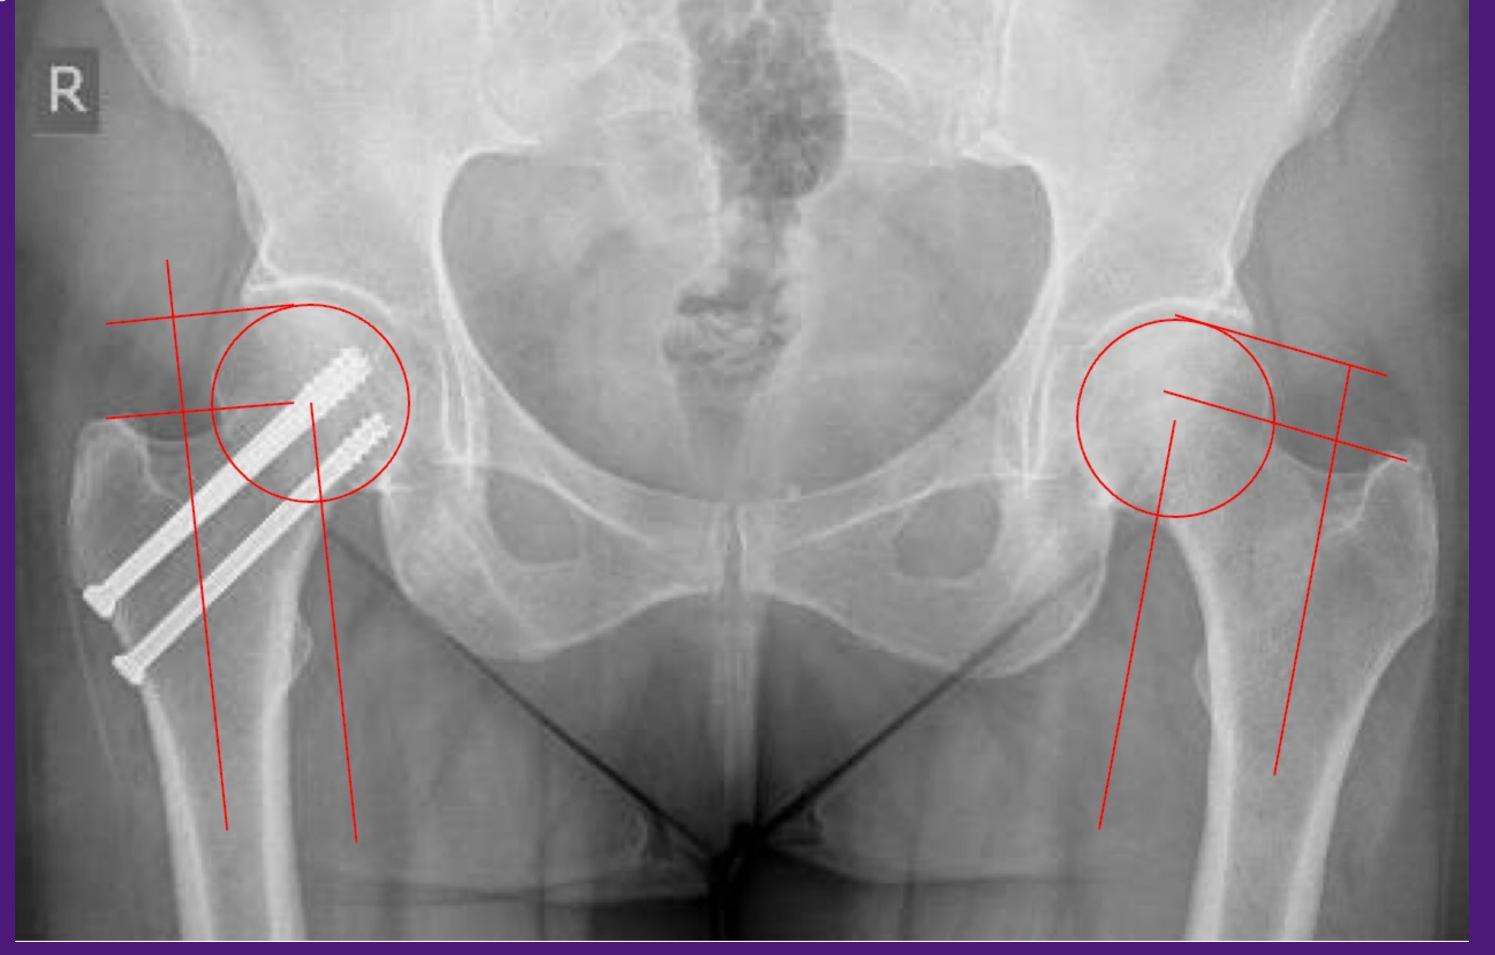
6-month post-operative AP Pelvis X-ray
